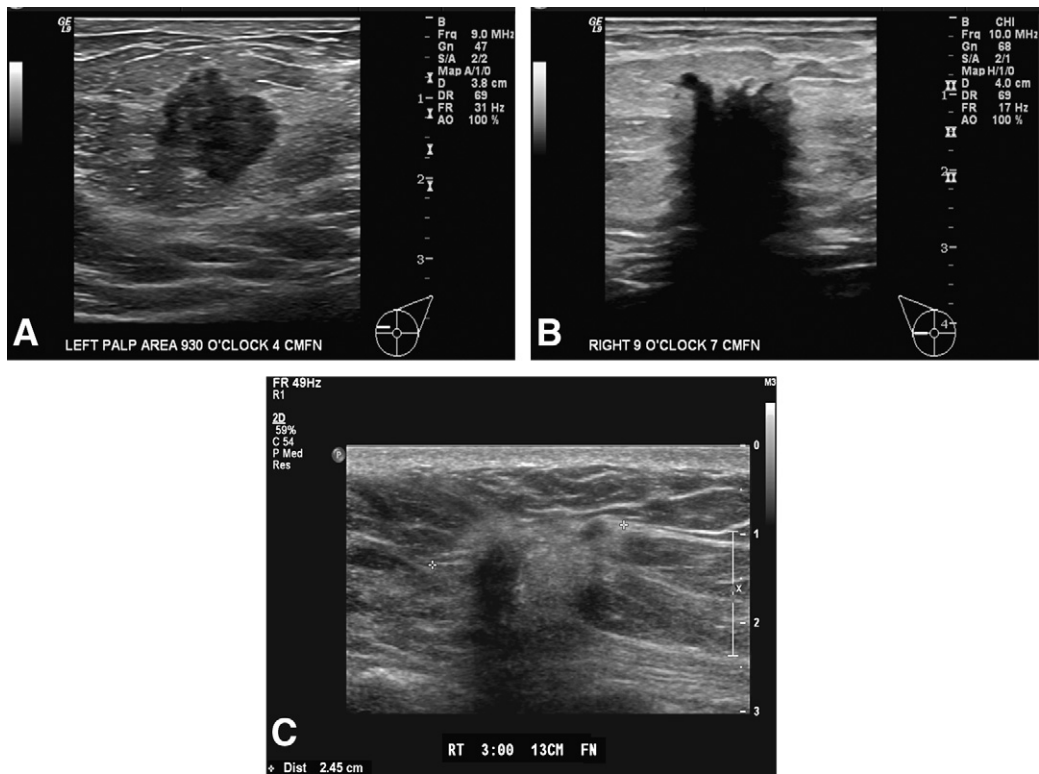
Transverse ultrasound (US) images. (A and B) Images showing lesions that were also detected on mammogram. Transverse sonographic image, showing a third lesion discovered on subsequent whole-breast US when using a different US machine (C). A 72-year-old woman presented with a palpable lump on the left breast. Pathology results proved invasive ductal carcinomas with prominent lobular features in all 3 lesions.
